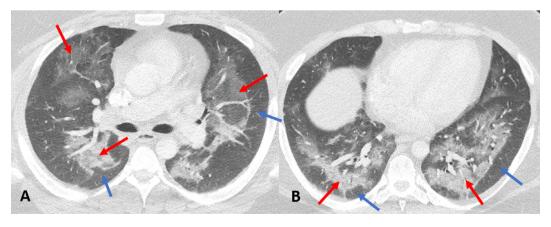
37 year-old-man presenting with low grade fever, cough, shortness of breath and O2 saturation of 92% on room air. Patients confirmed marijuana vape use in the past month before admission. RT-PCR for COVID-19 pneumonia as well as all cultures and infectious assessments were negative. Electronic-cigarette, or vaping, product use-associated lung injury (EVALI) was the final diagnosis by excluding other causes. Non-contrast CT images show extensive GGO in both lungs with slight lower lung predominance (red arrows in A and B). As compared to the case in Fig. 1, there is a distinct area of subpleural sparing (blue arrows). (For interpretation of the references to colour in this figure legend, the reader is referred to the web version of this article.).
